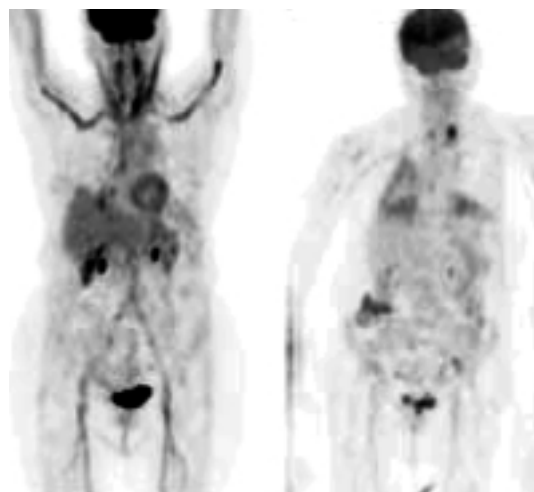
Giant cell arteritis showing altered distribution of FDG.
